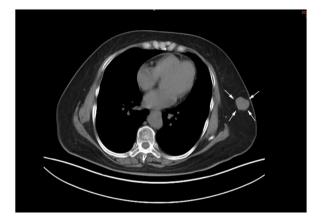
A staging CT demonstrated a space-occupying lesion (white arrow) with a defined boundary in the outer quadrant of the left breast.
